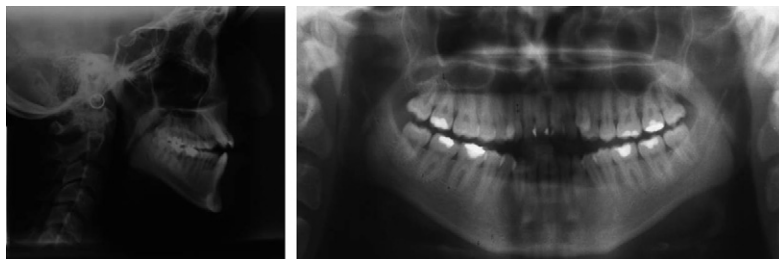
Initial cephalometric and panoramic radiographs of case 2.
